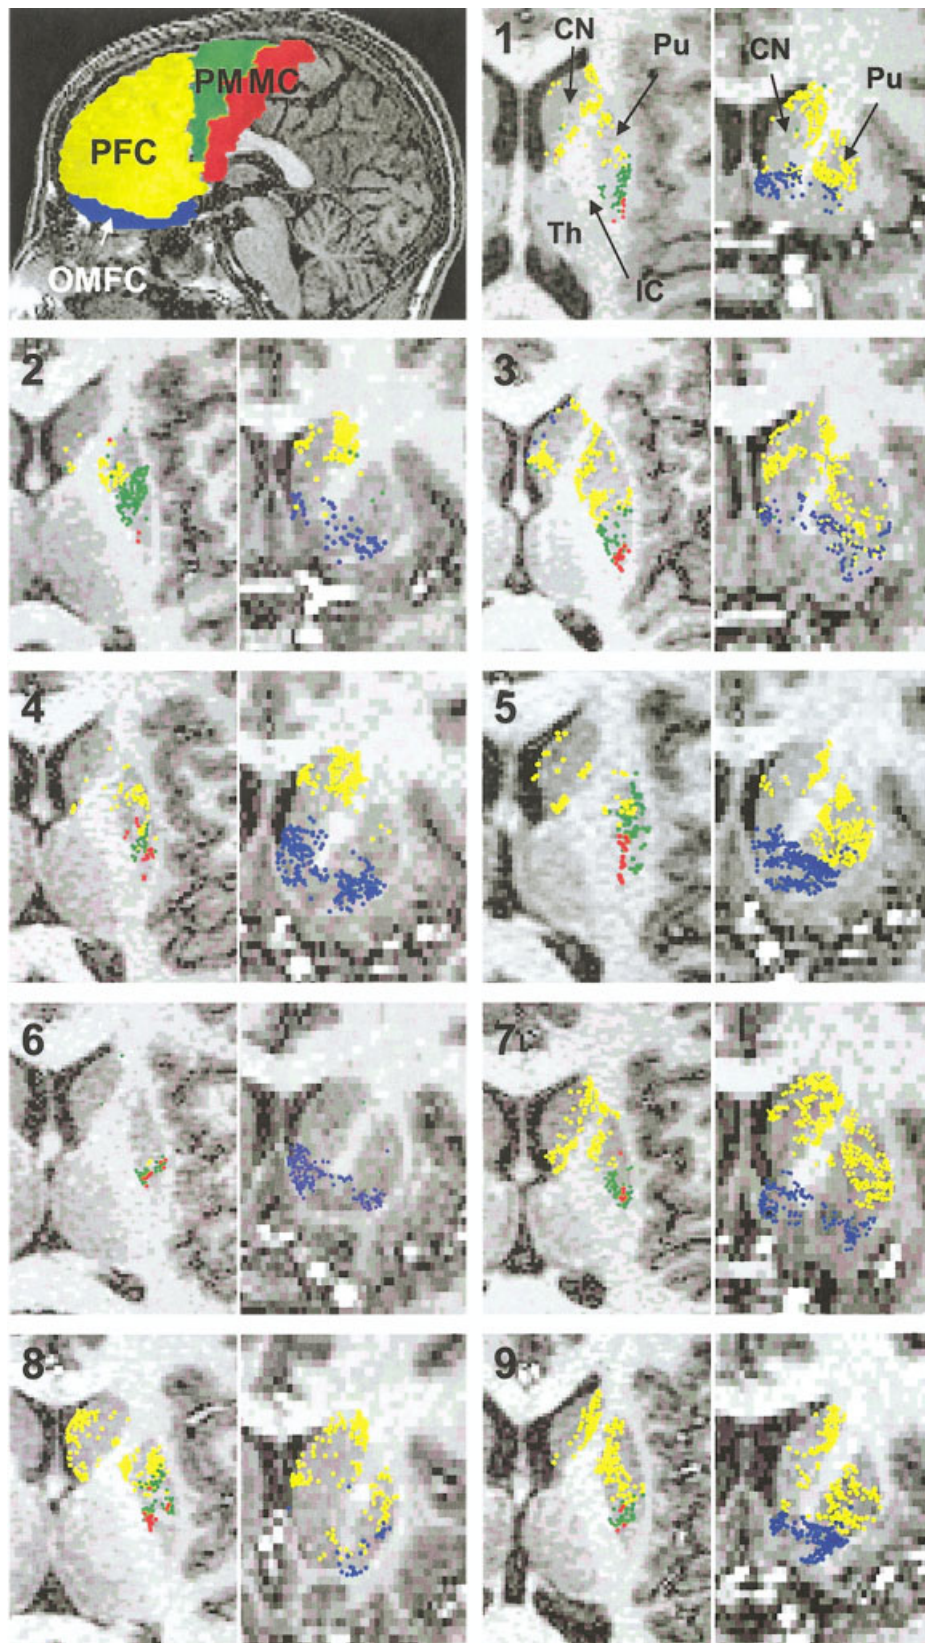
Connectivity maps of the striatum. (A) Tracking was initiated from four regions of interest located in the frontal lobes, including the motor (red), pre-motor (green), prefrontal (yellow), and orbitomedial frontal cortex (blue) in the left hemisphere of all subjects. Only fibers crossing the striatum are displayed in the axial (left) and coronal (right) planes as a small dot superimposed on T1-weighted anatomical images. Fibers originating from the motor cortex were directed to the posterior part of the putamen (red). Premotor fibers were rostral to motor fibers although overlapping with these fibers (green). Fibers originating from the prefrontal cortex occupied most of the anterior striatum and the head of the caudate nucleus (yellow). Fibers originating from the orbitomedial frontal cortex were directed to the ventral striatum (blue). Variable overlap existed between the different striatal territories. CN = caudate nucleus; IC = internal capsule; MC = motor cortex; OMFC = orbitomedial frontal cortex; PFC = prefrontal cortex; PM = premotor cortex; Pu = putamen; Th = thalamus.
